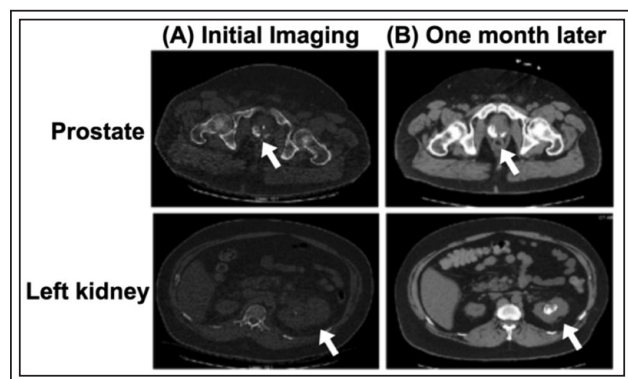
Rapidly progressive urinary tract calcification. Column (A) shows a CT scan of the abdomen and pelvis with arrows indicating prostatic calcifications and left hydronephrosis. Column (B) shows a repeat CT scan one month later. Arrows indicate worsening prostatic calcification, left hydronephrosis, and large staghorn calculus.
